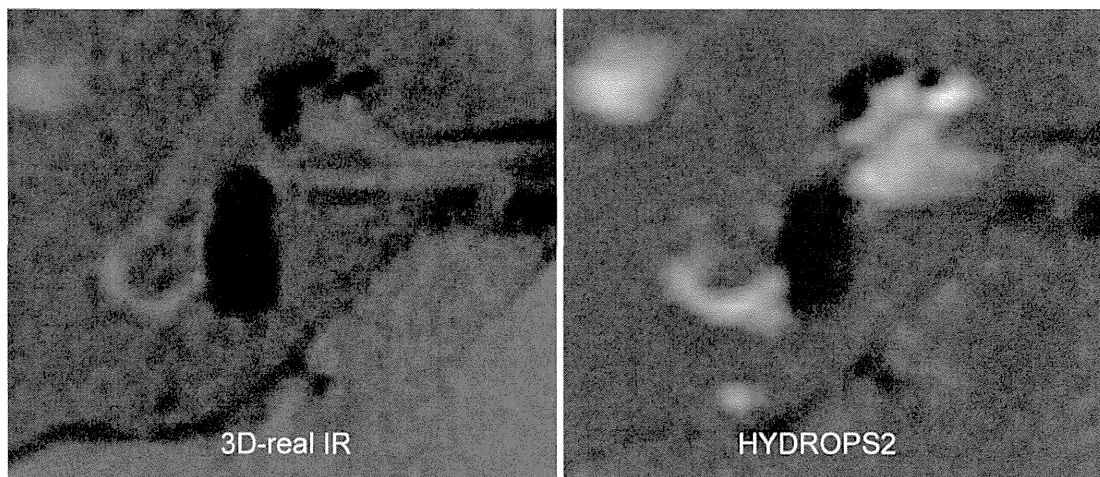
A 44-year-old man. Intratympanic and intravenous (IT + IV) side. Note the far weaker enhancement of the perilymph on 3-dimensional (3D)-real inversion recovery (IR) than HYDROPS2 (hybrid of reversed image of magnetic resonance cisternography and positive perilymph signal by heavily T₂-weighted 3D-fluid-attenuated inversion recovery [FLAIR]). However, significant endolymphatic hydrops (EH) can be appreciated in the cochlea and vestibule on both images.
